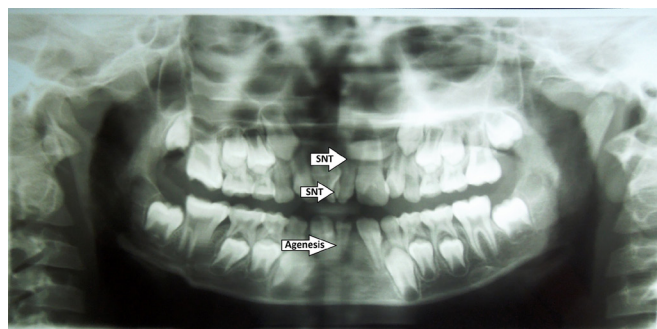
Orthopantomogram showing concomitant hypohyperdontia. SNT, supernumerary tooth.
